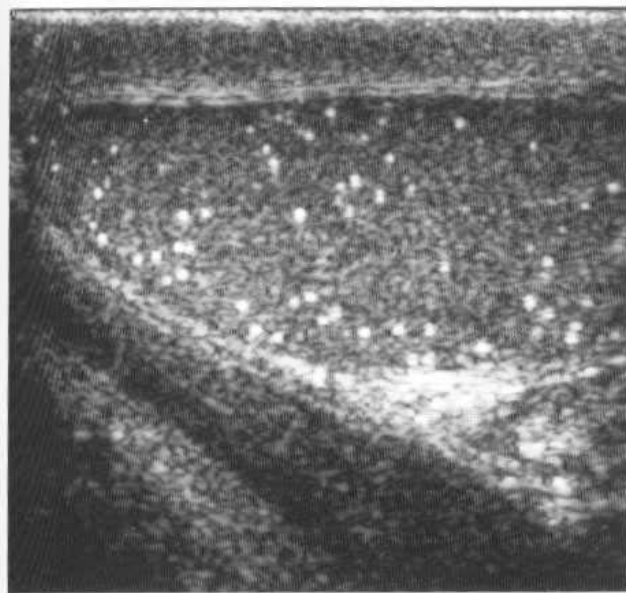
Ultrasound of testicular microlithiasis showing numerous tiny calcific foci.
